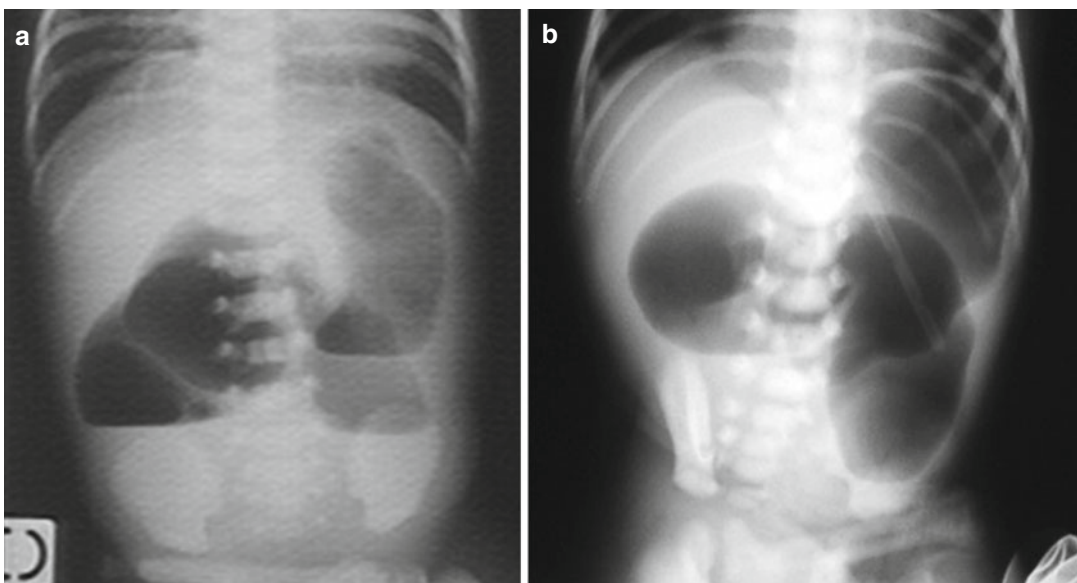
(a–b) Frontal plain films show jejunal atresia along with intestinal occlusion. “Triple bubble” sign (b)
